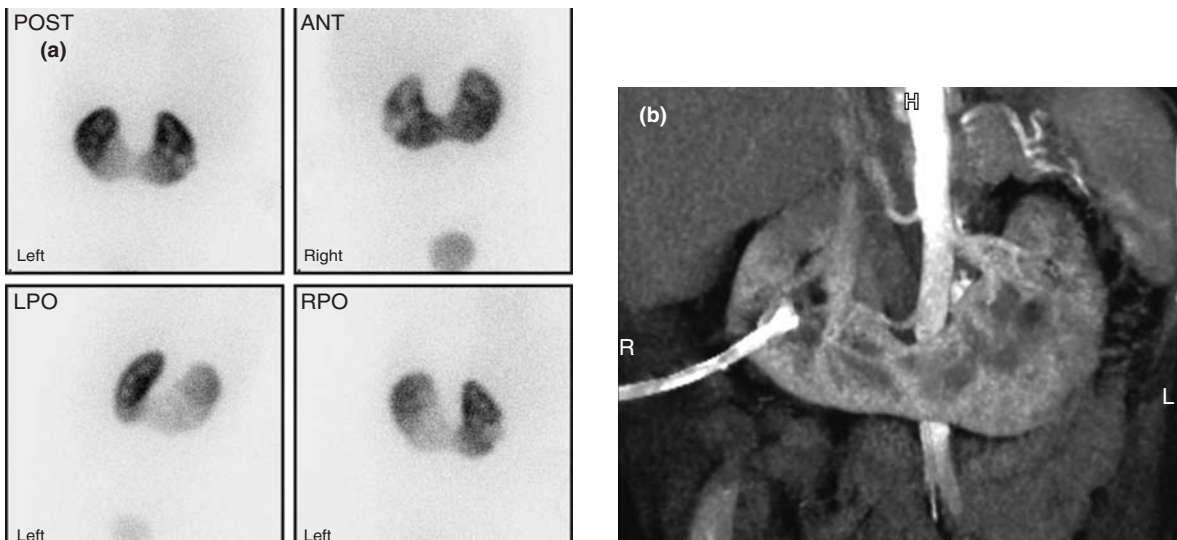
Horseshoe kidney. (a) DMSA demonstrates the presence of functioning renal tissue across the midline in this patient. (b) Coronal reconstruction from a CT angiogram for vascular anatomy presurgery also demonstrates the configuration of the kidney (a nephrostomy tube is in place in the right moiety).
